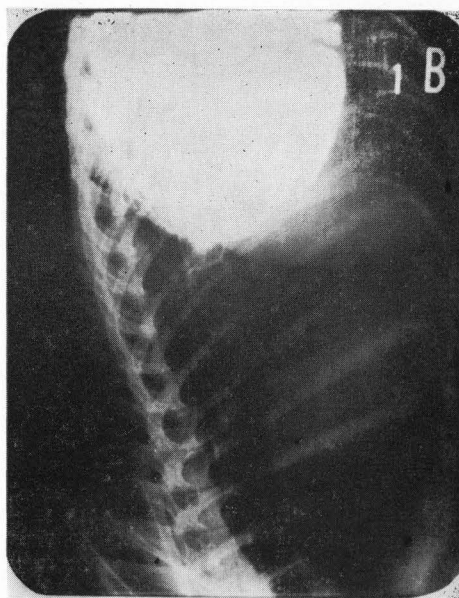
No reflux with steep Trendelenburg position was proved by X-ray examination.
